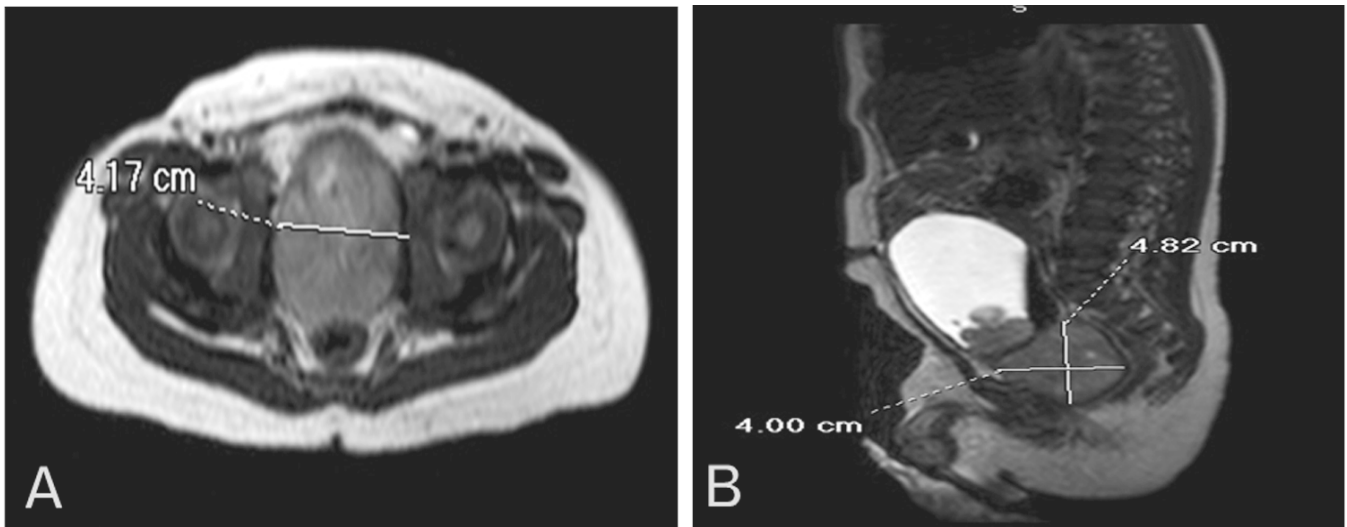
Non-contrast abdominal MRI. A (Transverse view) & B (Sagittal view). Predominantly solid mass in the pelvic region, likely involving the prostate gland and anterior to the rectum, measuring about 4.8cm x 4.0cm x 4.2cm.
